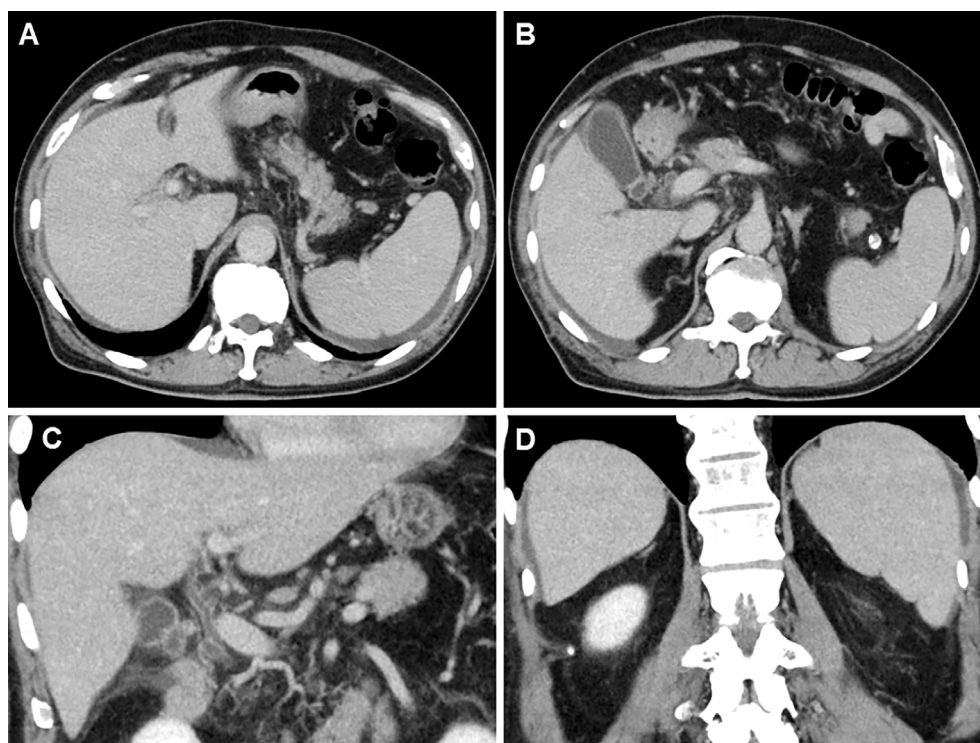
Contrast-enhanced computed tomography findings of the abdomen. Ascitic fluid accumulation on the liver surface was observed. No signs indicating liver cirrhosis, intrahepatic masses, bile duct dilatation, or biliary obstruction were detected (A-C). Splenomegaly was noted (D).
